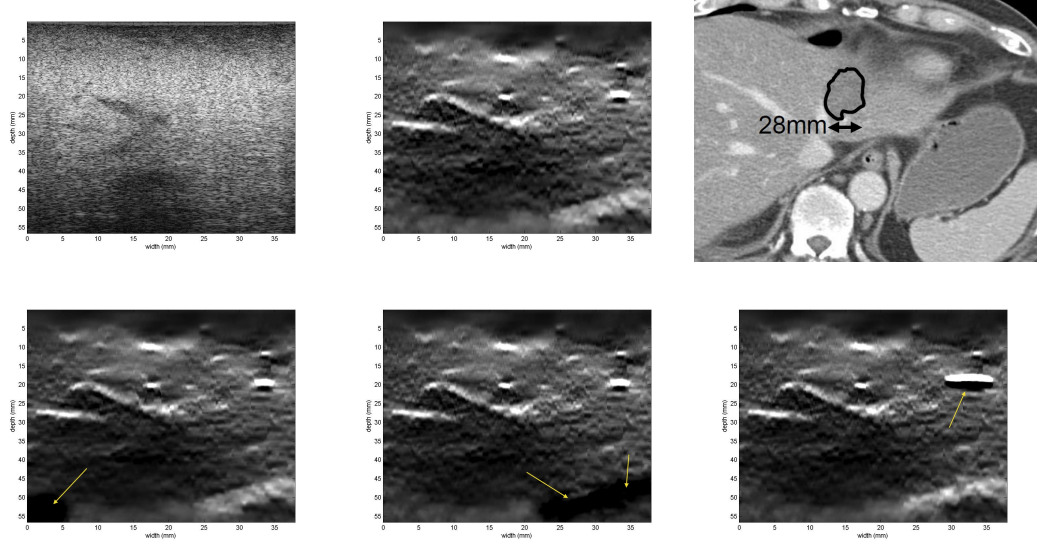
RF ablation therapy of liver cancer patient 2. All imaging was acquired after the ablation. B-mode (a), Elastography with the robust method (b) - The thermal lesion shows in as dark, surrounded by normal tissue in white., CT with delineated thermal lesions (c) and Elastography without the robust method (d-f).
